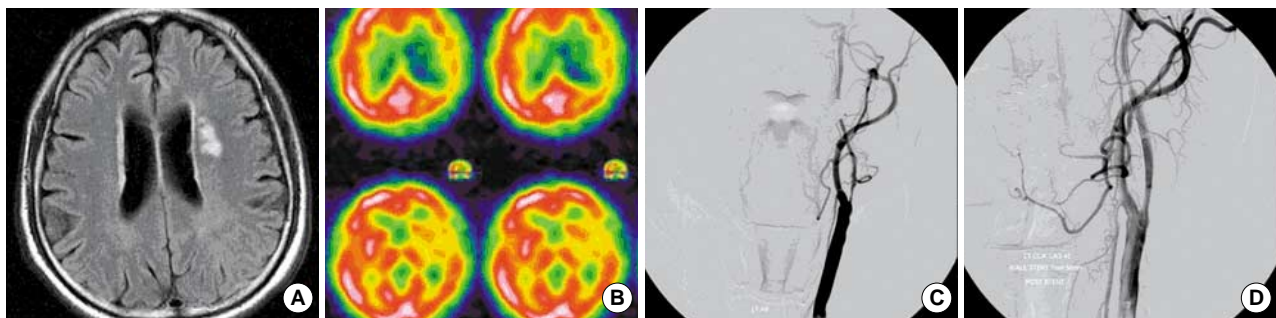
Images obtained in patient 3, (A) FLAIR image showing small ischemic lesions in the left deep white matter area. (B) Brain SPECT showed hypoperfusion on the left fronto-temporo-parietal area. (C) Carotid angiogram showing severe stenosis of the proximal internal carotid artery and (D) DSA after stent placement.
